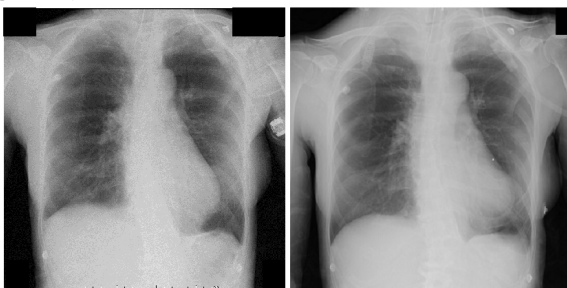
Case 2. Chest radiography obtained after the first re-intubation on post-operative day 1 (a), and after the second re-intubation on the same day (b), showing enhancement of the soft tissue shadow in both upper lung fields after the second re-intubation.
